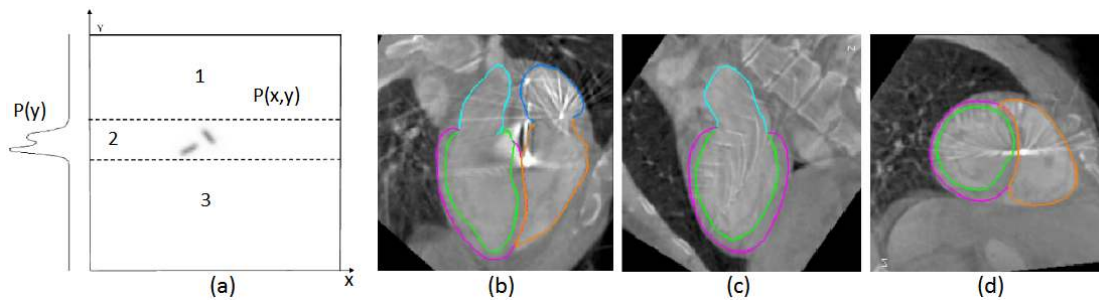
MSL-based segmentation of 3D cardiac CT volumes. (a) MSL, and (b-d) extracted heart chamber in axial, sagittal, coronal views with green for LV endocardium, magenta for LV epicardium, cyan for LA, brown for RV, and blue for RA [140].
